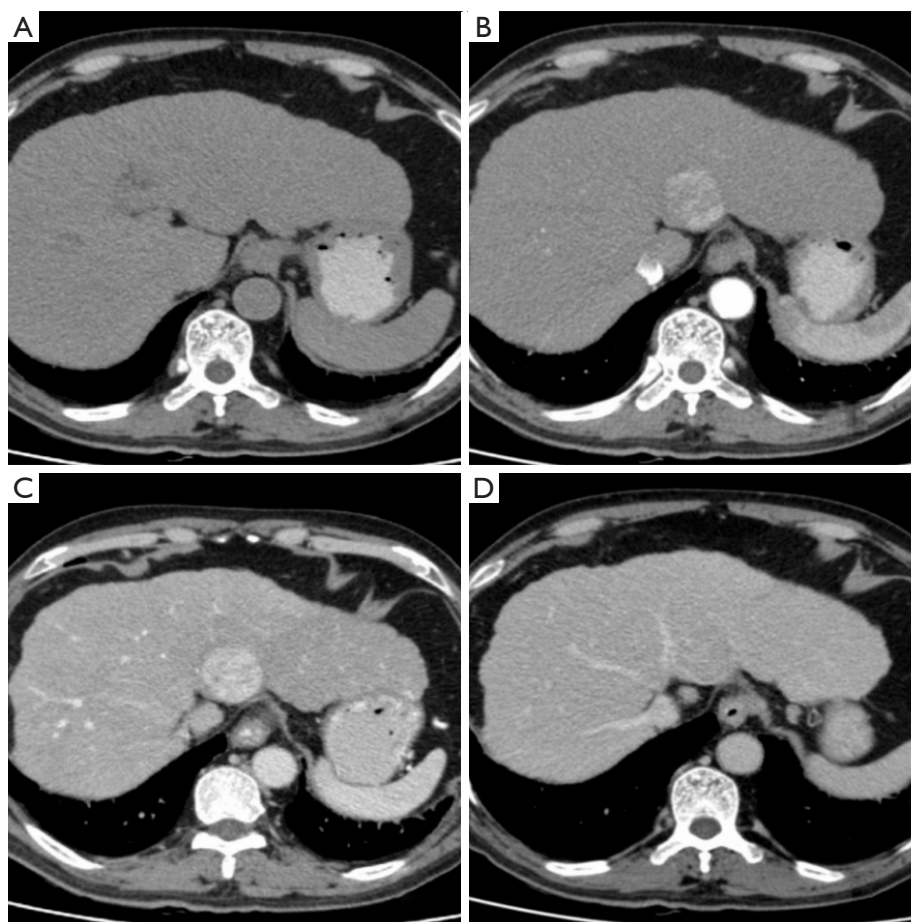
Liver CT contrast images of a 72-year-old male patient. (A) The plain scan showed a round-like equidensity nodule shadow at the S4 segment of the left lobe of the liver. The border was not clear. (B-D) The arterial phase was significantly enhanced unevenly. The portal phase was continuously enhanced, and the enhanced density in the delayed phase was reduced. CT, computed tomography.
